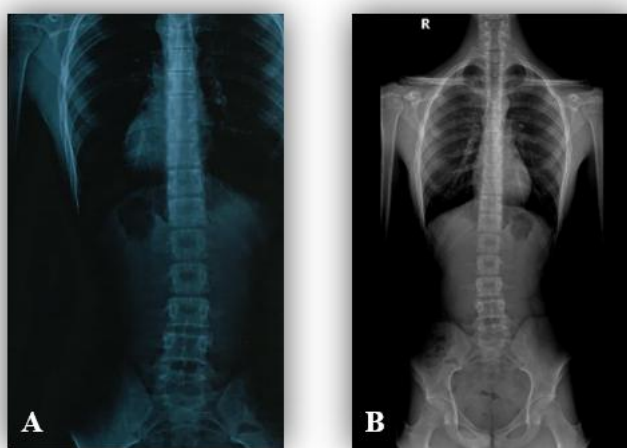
Radiographic images of 16-year-old female (A) and 14-year-old (B) tennis players.
